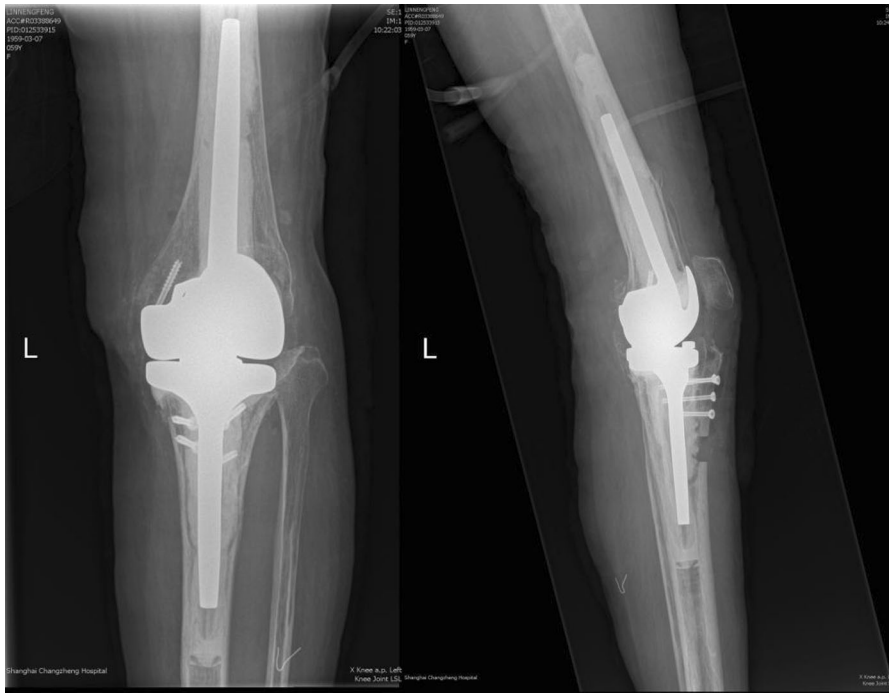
Postoperative radiographs showing well-fixed prosthesis
